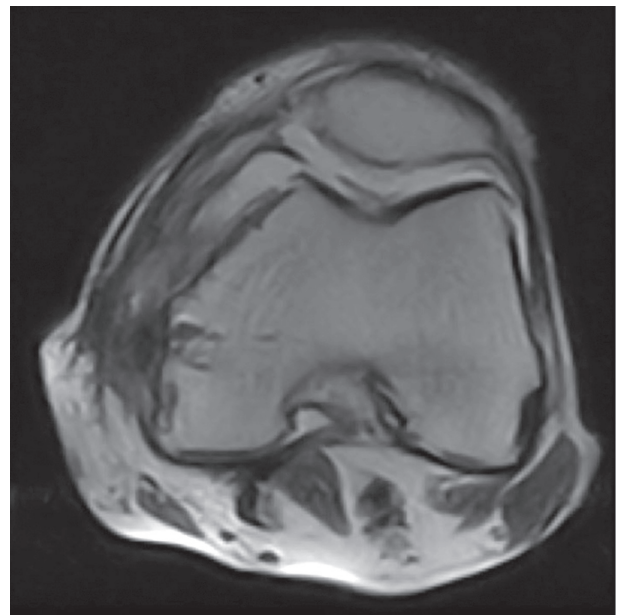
Preoperative MRI of the left knee showing patellofemoral joint of left knee in good shape
